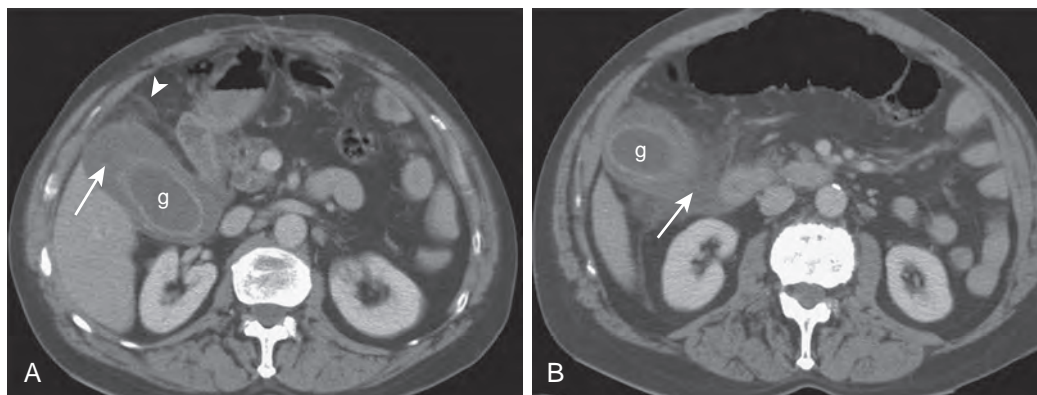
Acute cholecystitis: CT features. A. The gallbladder lumen (g) is distended with marked mural thickening (arrow) and pericholecystic inflammatory changes (arrowhead). B. Slightly more inferior image demonstrates pericholecystic fluid (arrow).
